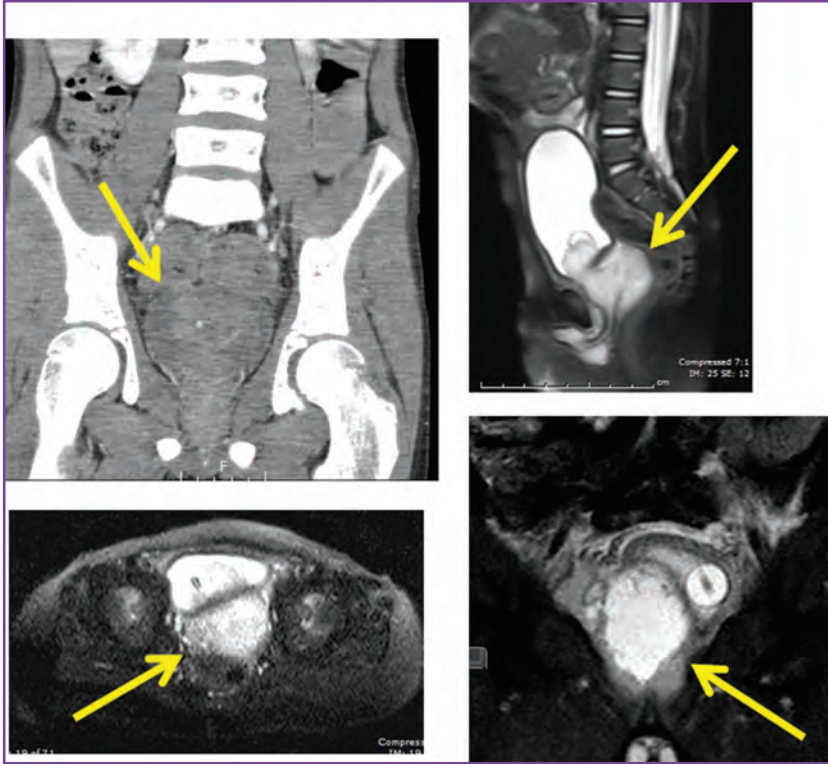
Magnetic resonance images of a large pelvic mass (arrows) displacing the bladder, which turned out to be a bladder and prostate rhabdomyosarcoma. Coronal (A), sagittal (B), and axial (C, D) images show the mass on different imaging planes.
